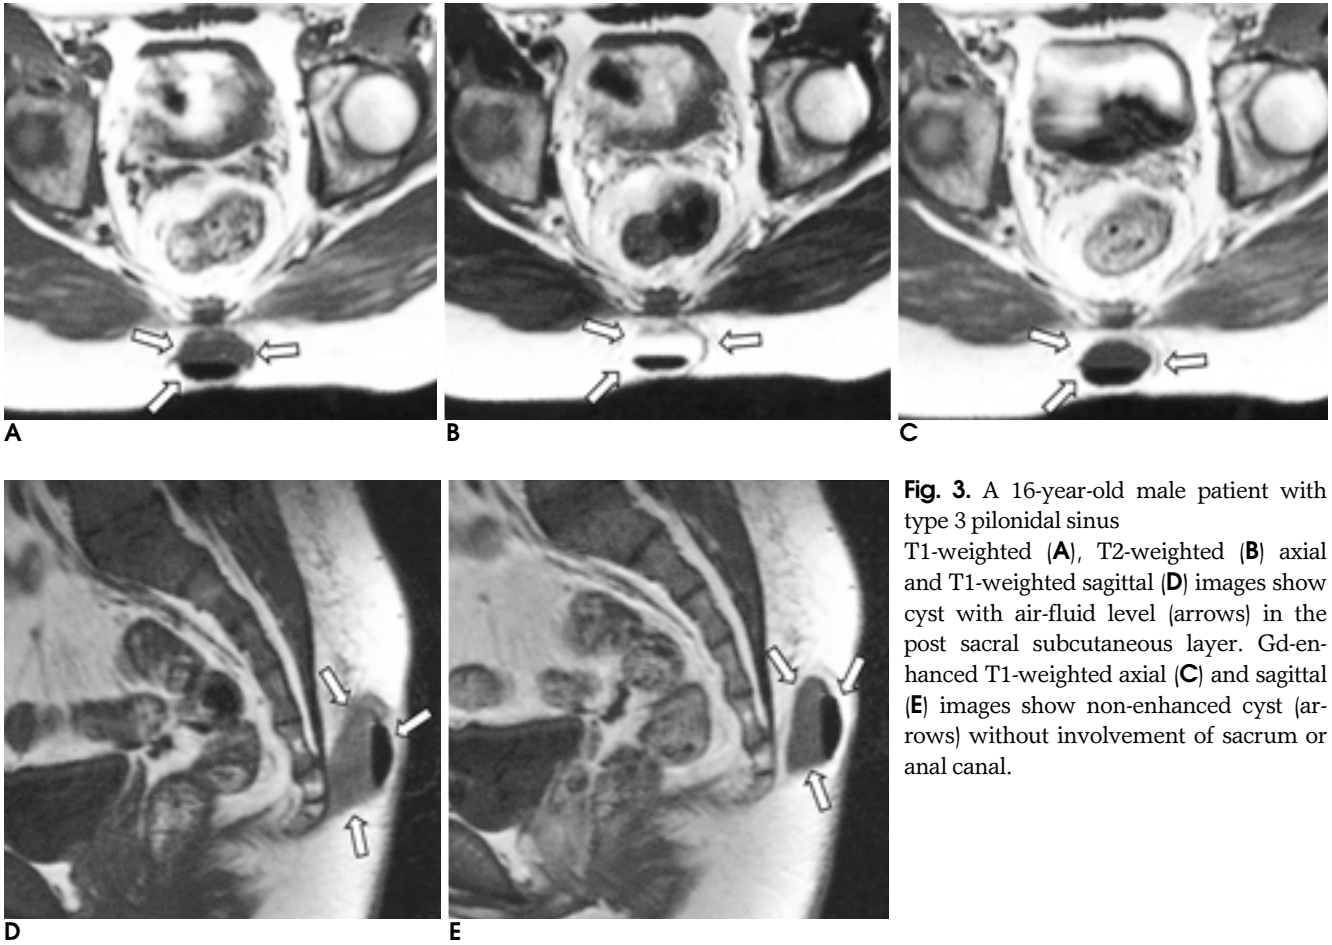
A 16-year-old male patient with type 3 pilonidal sinus. T1-weighted (A), T2-weighted (B) axial and T1-weighted sagittal (D) images show cyst with air-fluid level (arrows) in the post sacral subcutaneous layer. Gd-enhanced T1-weighted axial (C) and sagittal (E) images show non-enhanced cyst (arrows) without involvement of sacrum or anal canal.
